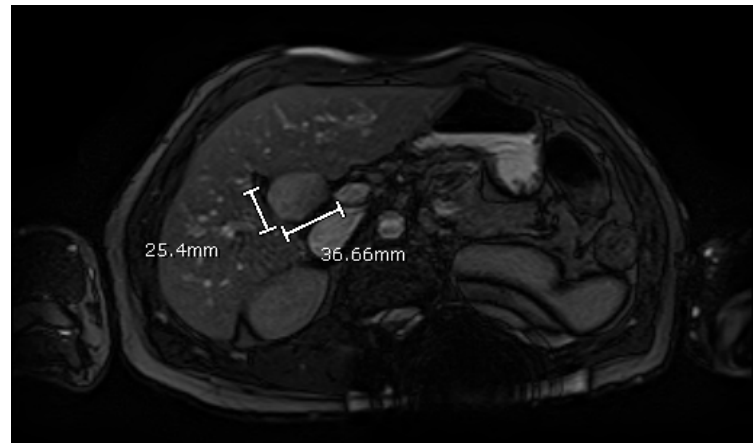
Magnetic resonance imaging of the abdomen showed a lesion measuring 25.40 mm x 35.66 mm compressing the porta hepatis.
